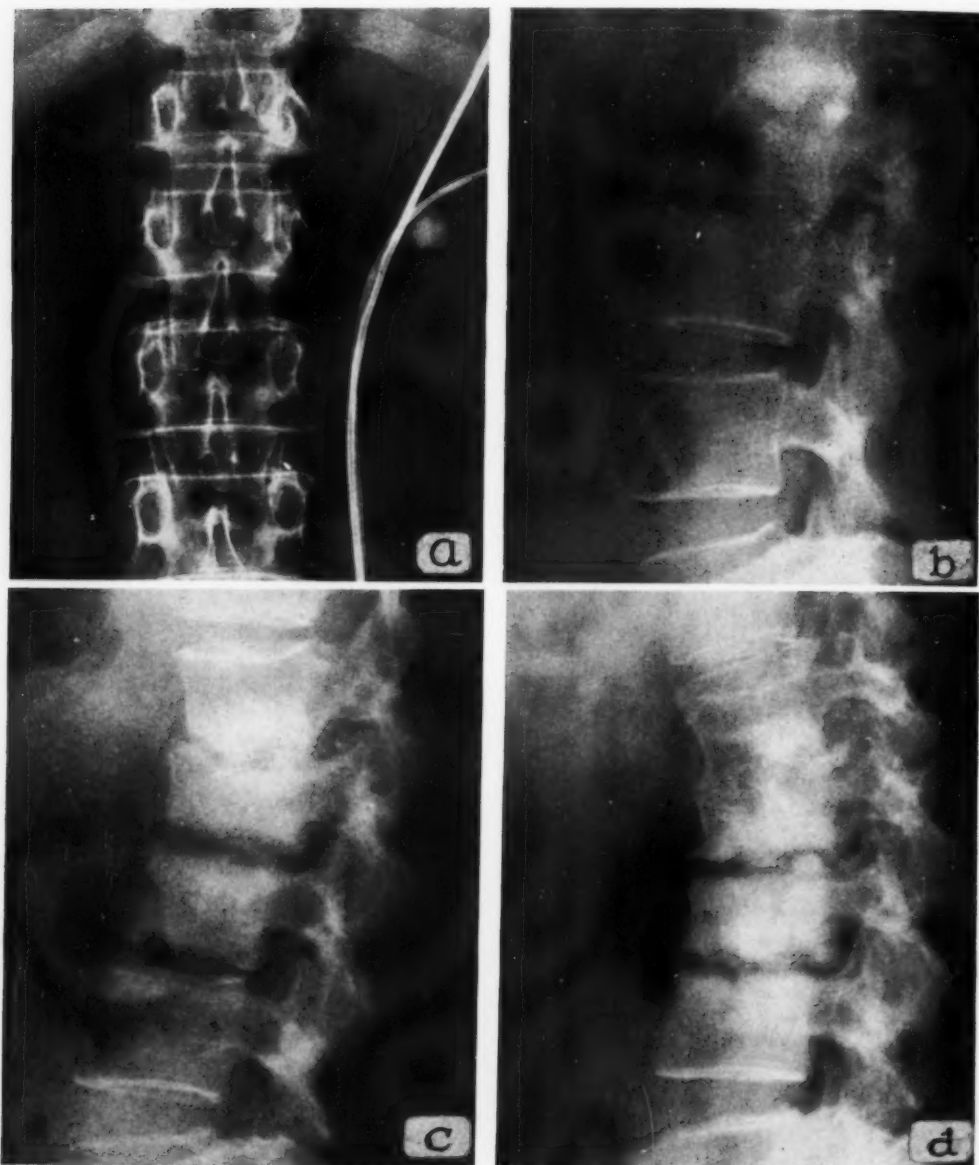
Case VII. a. Detail of a roentgenogram made during retrograde cystoscopy on March 30, 1949, showing a calculus in the left kidney pelvis. No osteomyelitis is present in the upper lumbar spine. b. A lateral film of the same area four months later, Aug. 2, 1949, now showing an inflammatory process at the L1-2 and L2-3 levels. The patient was then complaining of back pain. c. Further destruction at the same two levels after two more months, with early changes at L3-4. d. Roentgenogram obtained March 1, 1950, eleven months following the urinary infection. Three levels are involved.
